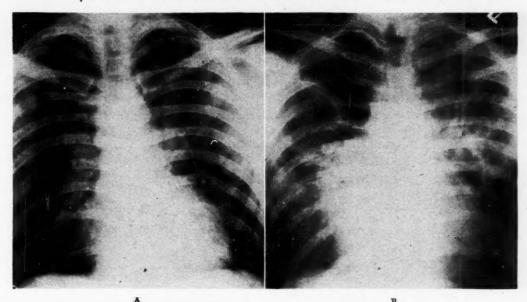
Case III. X-rays of the chest on third (A) and seventeenth (B) hospital days.
